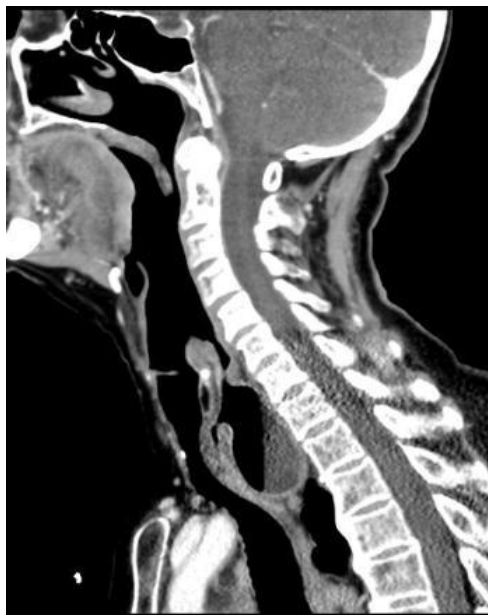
Cervico-thoracic CT scan showing a cervical retroesophageal mixed content formation suggestive of a Zenker diverticulum on a sagittal section
